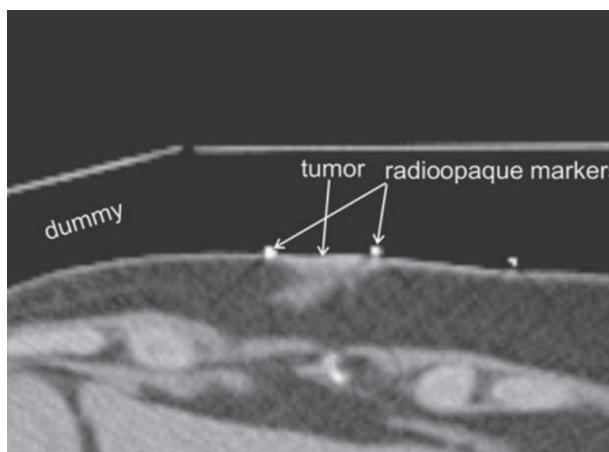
Axial CT image demonstrating a tumor marked with a radioopaque marker and a dummy water bolus (not visible on CT scan).
